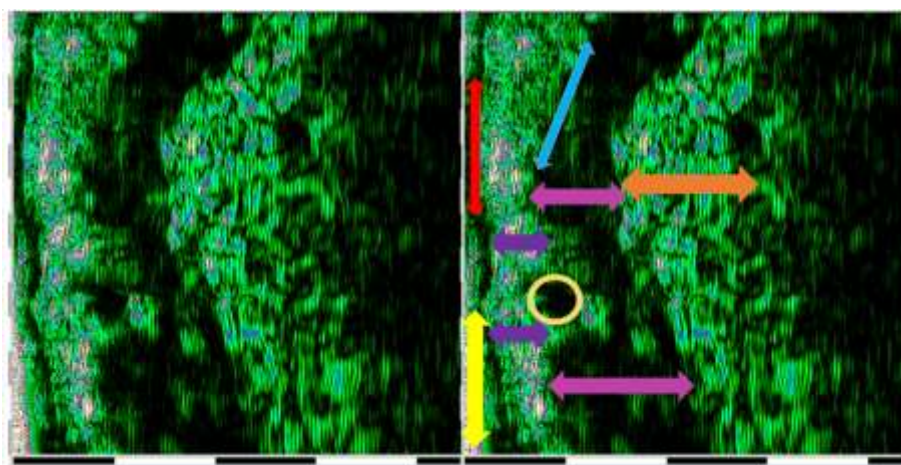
HFU ultrasound assessment (DUB® cutis, Taberna Pro Medicum) of the lower lip structures. yellow arrow - superficial layer of non-keratinized squamous epithelium red arrow - spinous and basal layers of non-keratinized squamous epithelium purple arrow - papillary and reticular layers of the lamina propria mucosae orange arrow - tela submucosa yellow circle - minor salivary gland pink arrow - orbicularis oris muscle.
